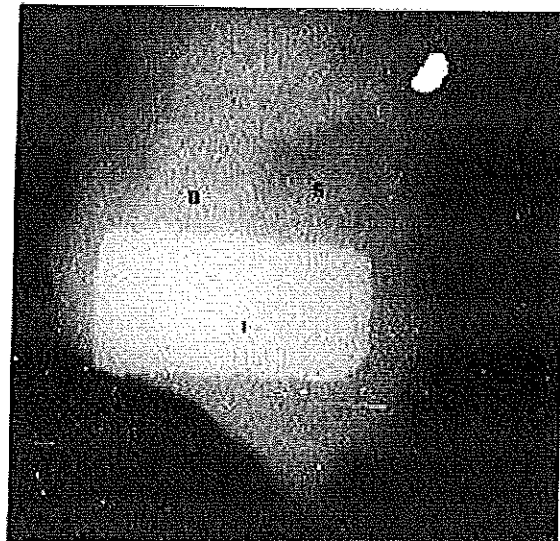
Sample contact radiograph of hydroxyapatite coated implant with 46 µg of recombinant human bone morphogenetic protein 2 after removal at 21 days. Note bony (B) apposition to implant (I) surface. Soft tissue (S) remains around the implant.
